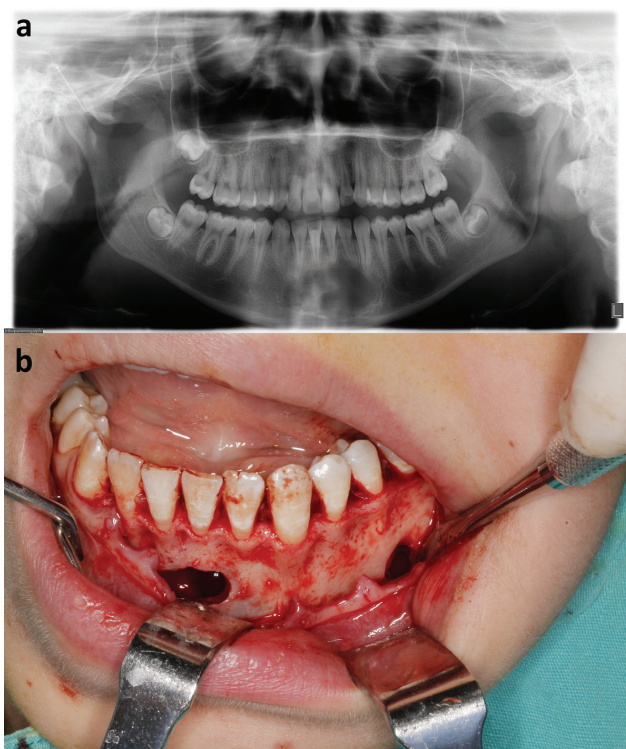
a) Radiographic view of the multifocal lesion at symphysis and left corpus regions; b) Intraoperative view of the TBCs
